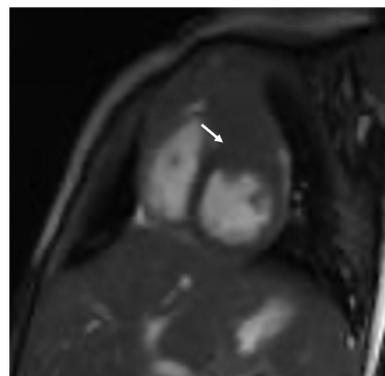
A 27-day-old female patient. Cardiac MRI balanced steady-state free precession sequence in short-axis shows an exophytic left ventricular cardiac rhabdomyoma (white arrow).
